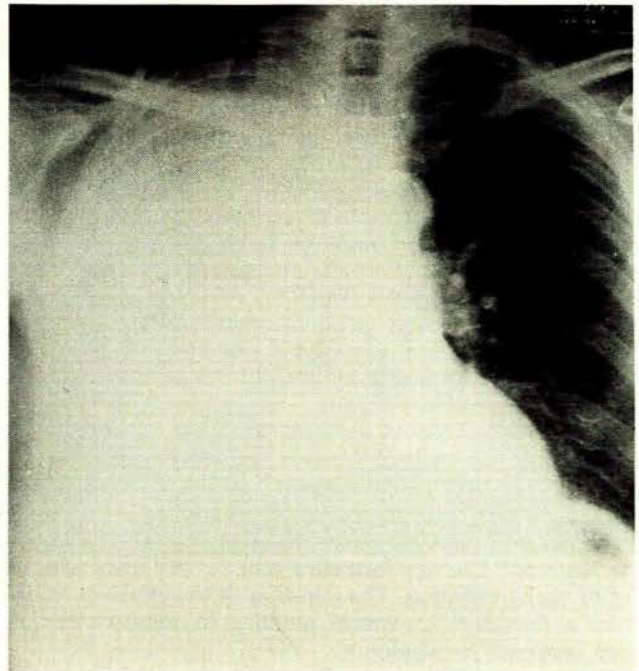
PA radiograph showing large right-sided pleural effusion.
